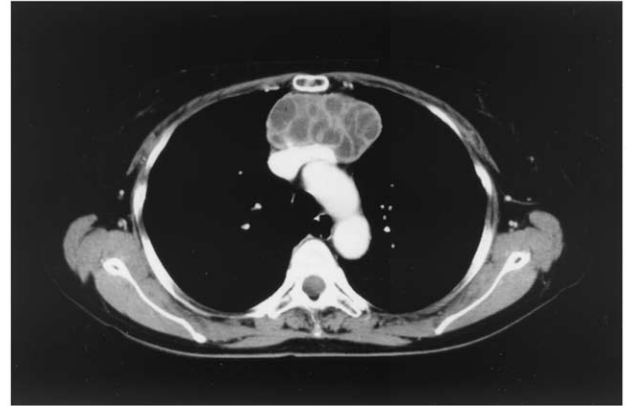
Computed tomography reveals an anterior and superior mediastinal mass with solid and cystic portions.
